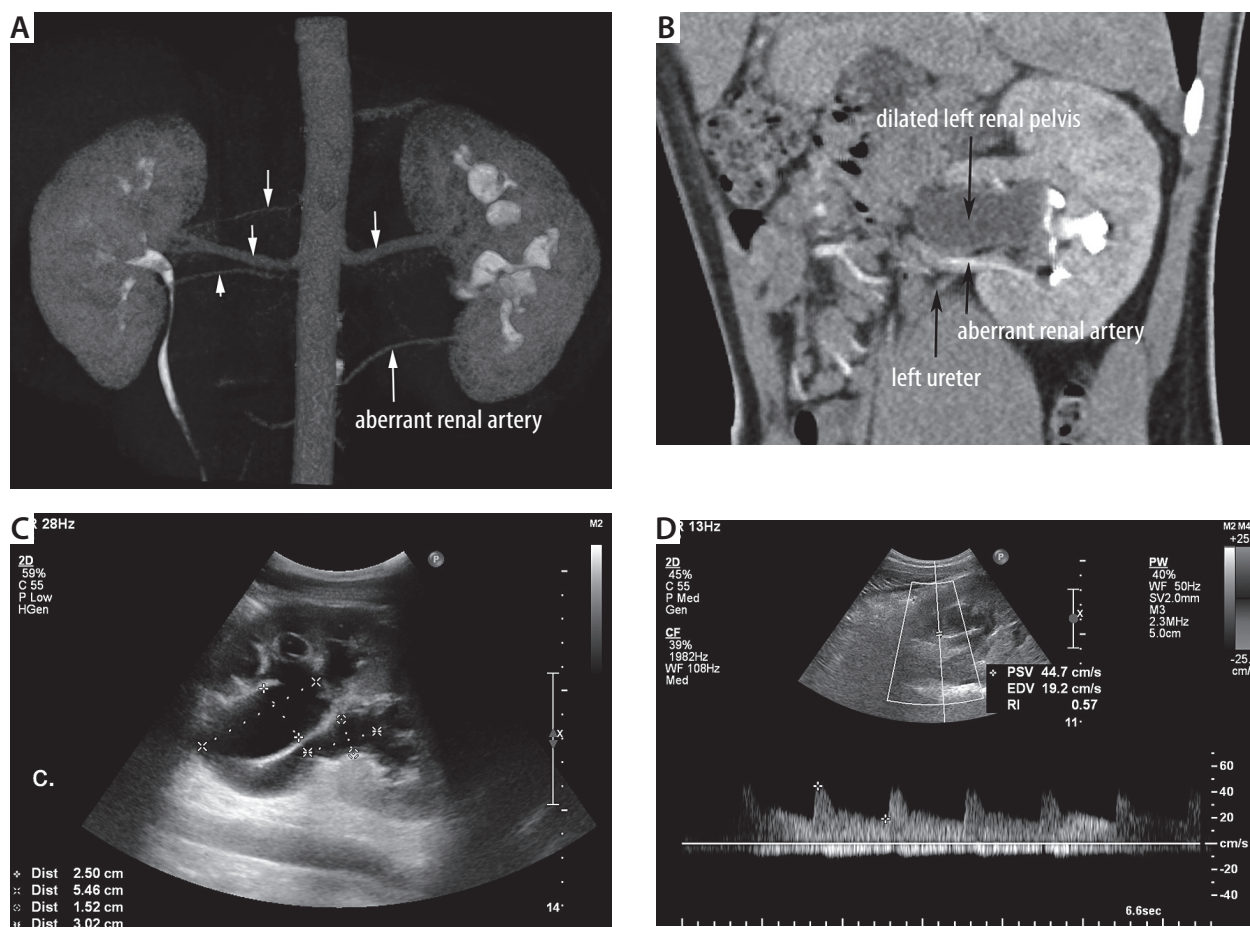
A), B) Computed tomography angiogram (CTA) demonstrates three arteries to the right kidney and two arteries to the left kidney, originating from the aorta (arrows). An inferior left additional artery is crossing over the ureteropelvic junction (arrows). C) Ultrasound scan shows a marked dilatation of the left pelvicalyceal system and partially separated, dilated left renal pelvis with dimensions 25 × 55 mm and 15 × 30 mm. D) Colour Doppler ultrasound shows an additional artery to the lower pole of the left kidney with normal blood flow (resistive index was 0.57)
